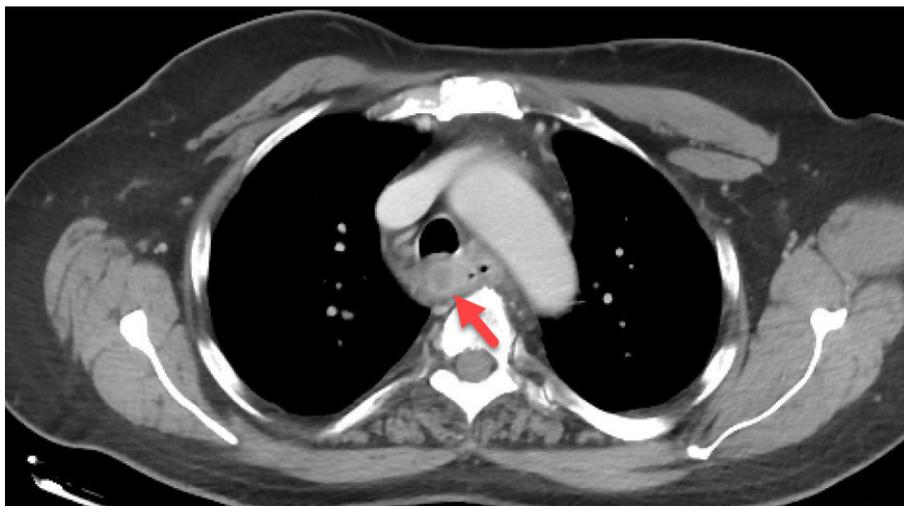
Follow up CT chest in a patient enrolled in advanced prostate cancer trial with evidence of new mediastinal node? Metastasis? Secondary Malignancy. Biopsy needed for confirmation.
